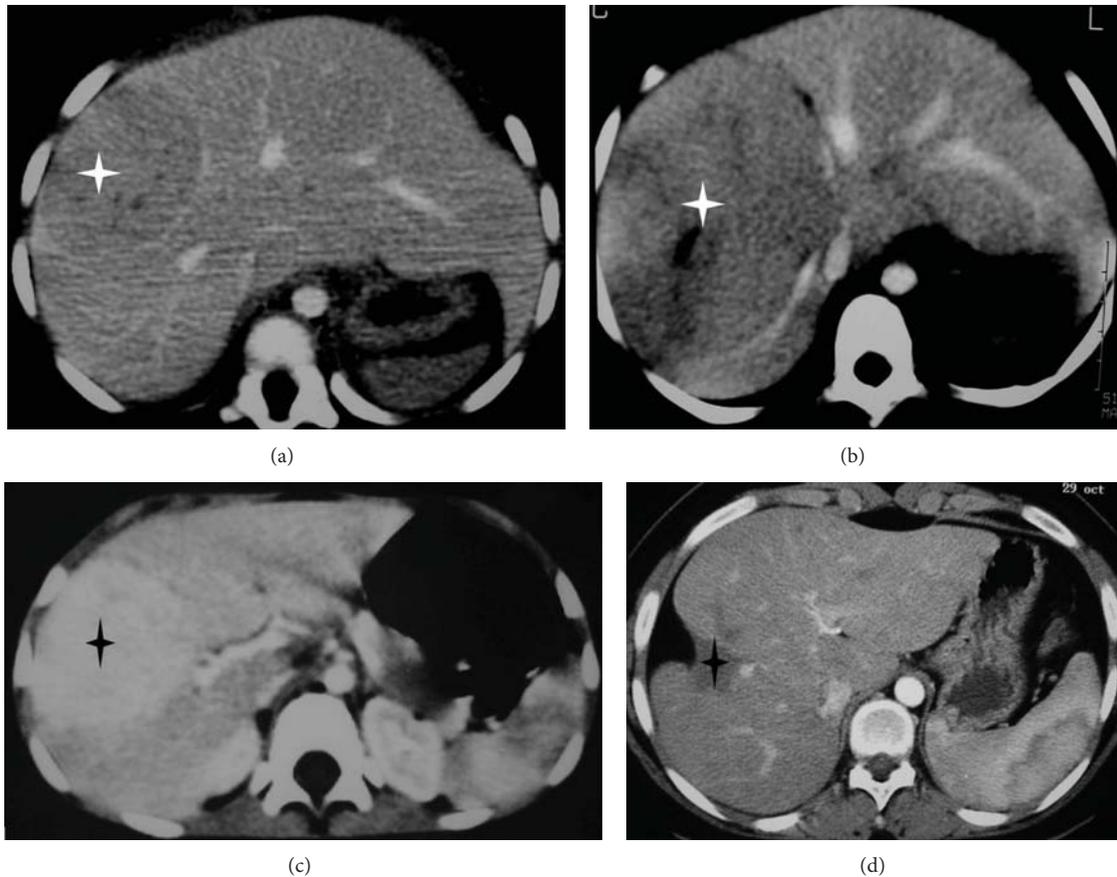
Spontaneous evolution of fortuitously discovered FNH in two children. (a) and (b): three-year-old girl with sickle-cell disease. CT scan after contrast injection at the portal phase at diagnosis (a). And three years later (b) shows growth of the tumor from 5 to 12 cm diameter. (c) and (d): eight-year-old girl. CT scan after contrast injection at diagnosis (c) and 12 years later (d) shows the spontaneous disappearance of the 5 cm diameter tumor with capsular retraction.
